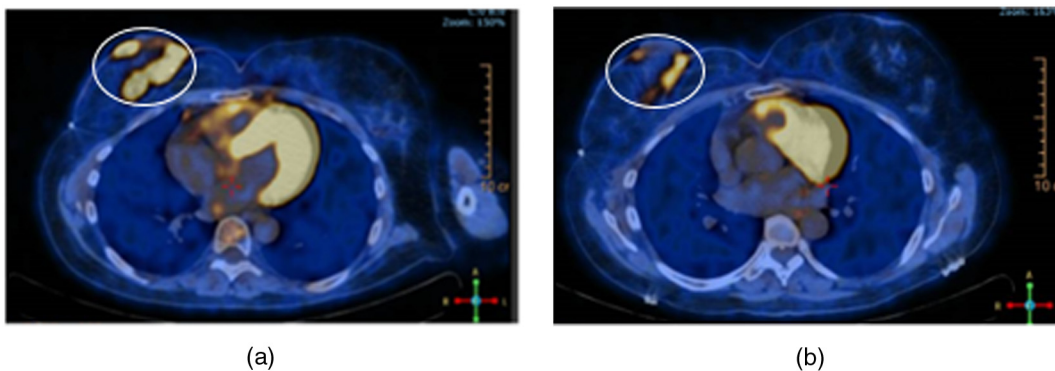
(a) CT-PET scan of patient #1 before radiation therapy and (b) CT-PET scan after treatment. There is a reduction in the affinity to 2-deoxy-2-[fluorine-18] fluoro-D-glucose.
